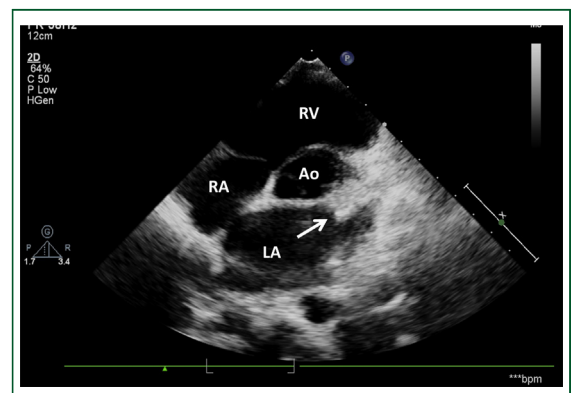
Parasternal short-axis view showing thrombus in left atrial appendage (arrow) in a patient with mitral stenosis. Abbreviations as in Figures 1 and 2.
